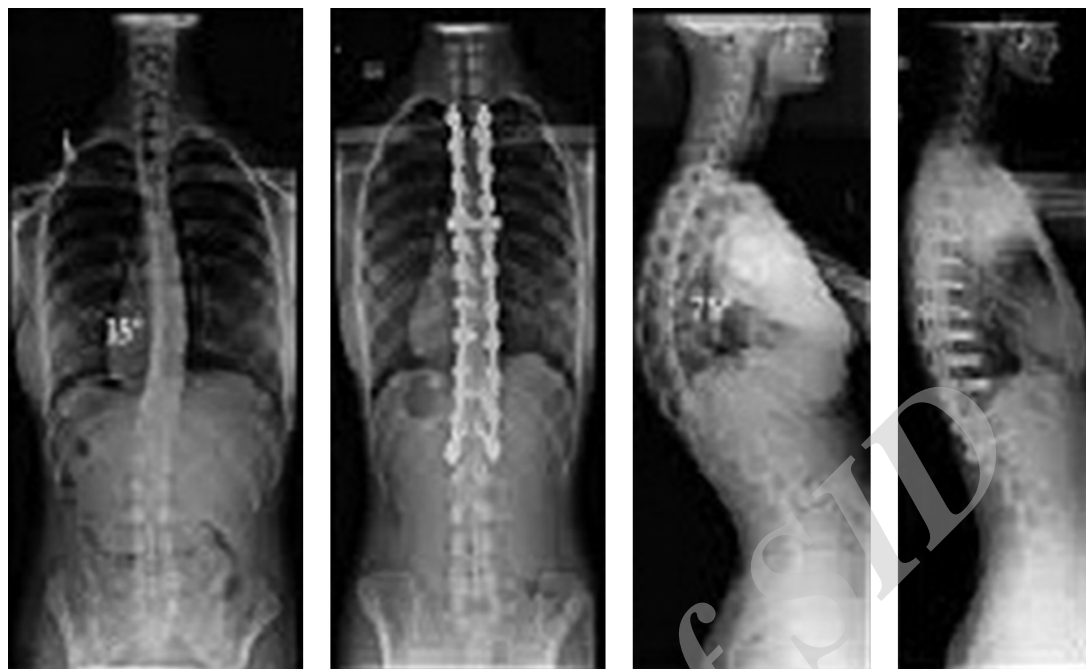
Comparative pre and post operation X-ray of the same patient with significant kyphosis correction
